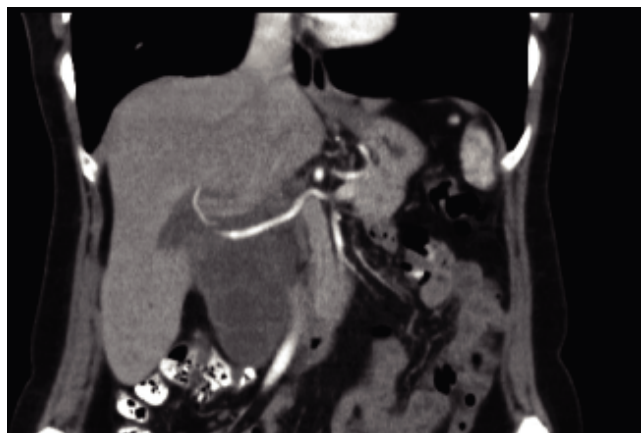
Coronal abdominal contrast computed tomography image and vascular reconstruction. The hepatic artery, originating from the celiac trunk, pass through the lesion without infiltration sings.
